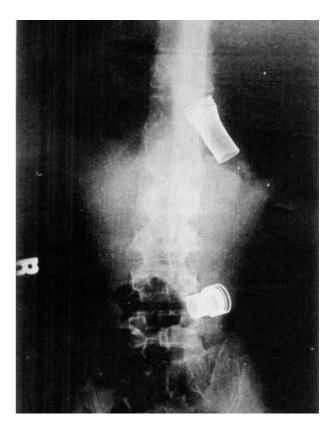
X-ray of abdomen showing a distal broken stent portion having migrated into the stomach.
